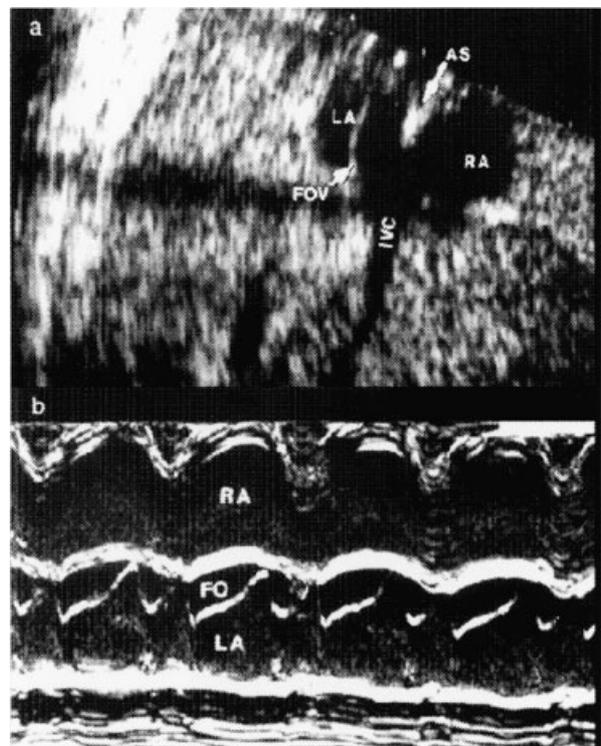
Ultrasound scan (a) showing that the fetal atrial septum (AS), at the level of the foramen ovale, is situated more towards the right atrium (RA) than in postnatal life, opposing the inferior vena cava (IVC). The entrance to the left atrium (LA) is formed as a ‘windsock’, delineated by the foramen ovale valve (FOV) towards the left, and the AS towards the right. M-mode (b) shows the changes in diameter of this ‘windsock’ (FO) during the heart cycle. From Kiserud T, Rasmussen S. 2001. Ultrasound assessment of the fetal foramen ovale. *Ultrasound Obstet Gynecol* 17: 119–124
